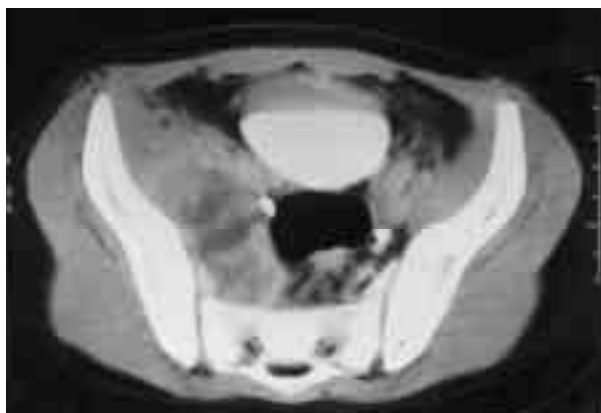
CT Abdomen and pelvis showing a large right psoas abscess.
